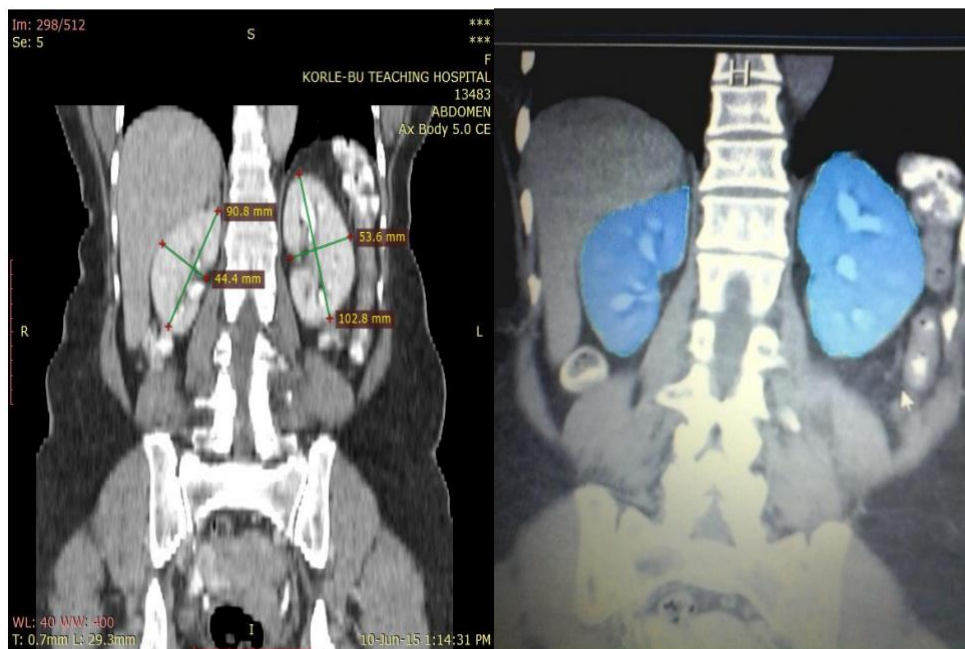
Abdominal CT images showing the kidney
